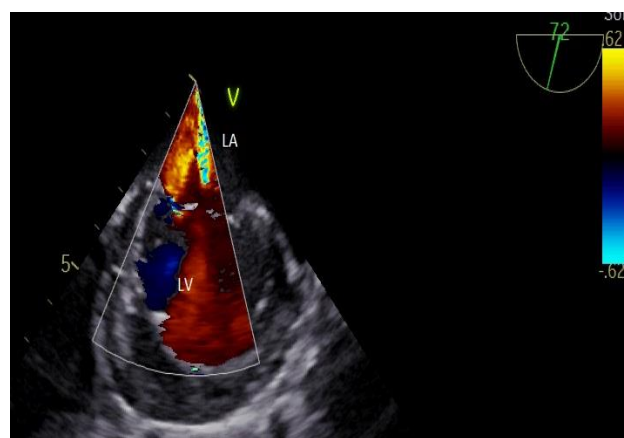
Mid esophageal 2 chamber TEE view (72 degree); color-Doppler revealed severe MR, with two jets reaching to the roof of the LA and LV was distended and hypokinetic (labelled).
